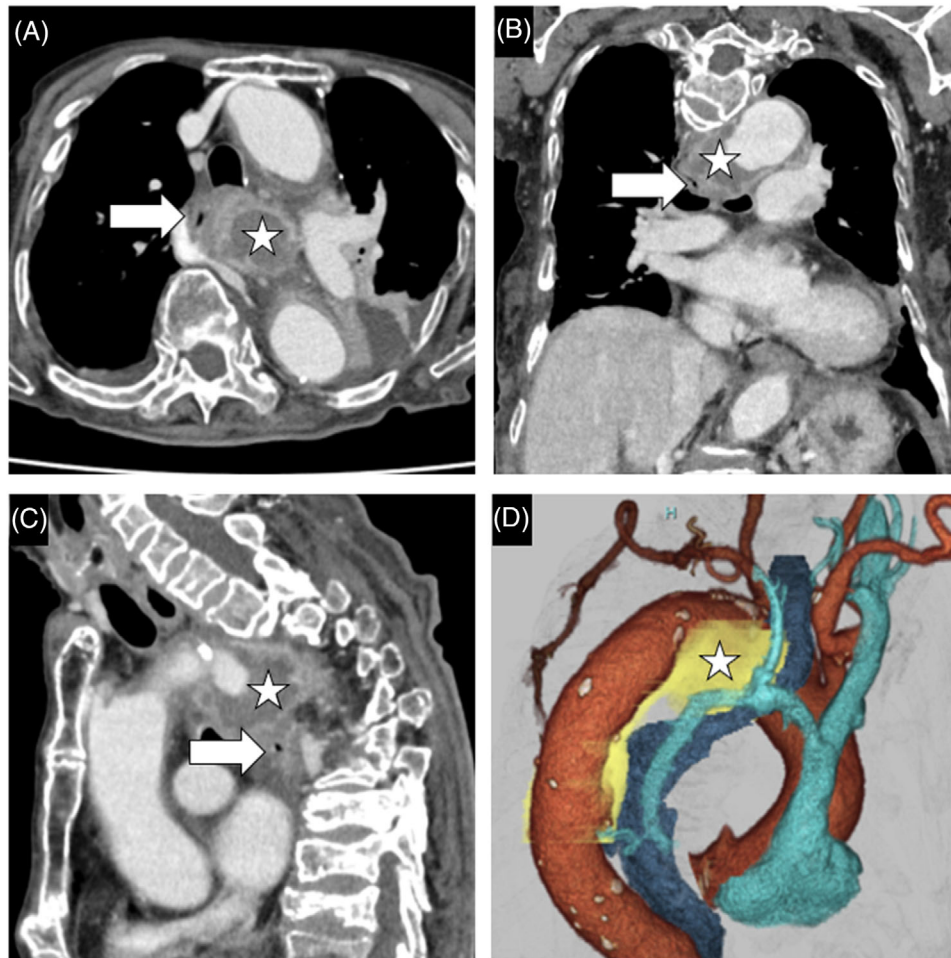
Axial (A), coronal (B), sagittal (C), and three-dimensional (D) computed tomography (CT) reconstruction images demonstrating extrinsic esophageal compression (arrow) by a sacular-shaped thoracic aortic aneurysm with periaortic soft tissue density (asterisk) at the arch of the aorta. Red area: aorta. Yellow area: aneurysm and abscess. Dark blue area: esophagus. Light blue area: vena cava.
